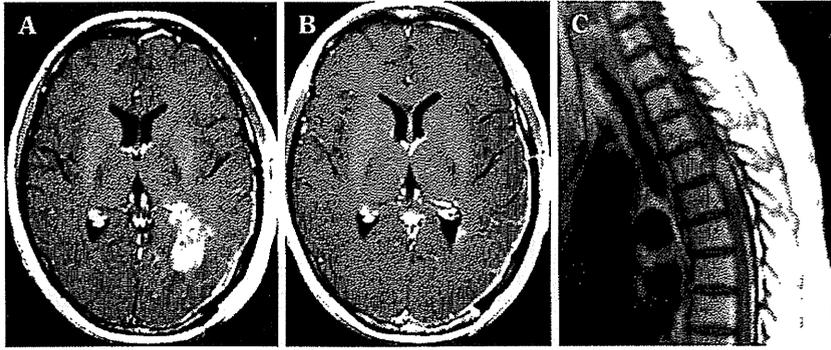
Periodic Gd-enhanced MRI findings of a GBM case treated by BNCT.
